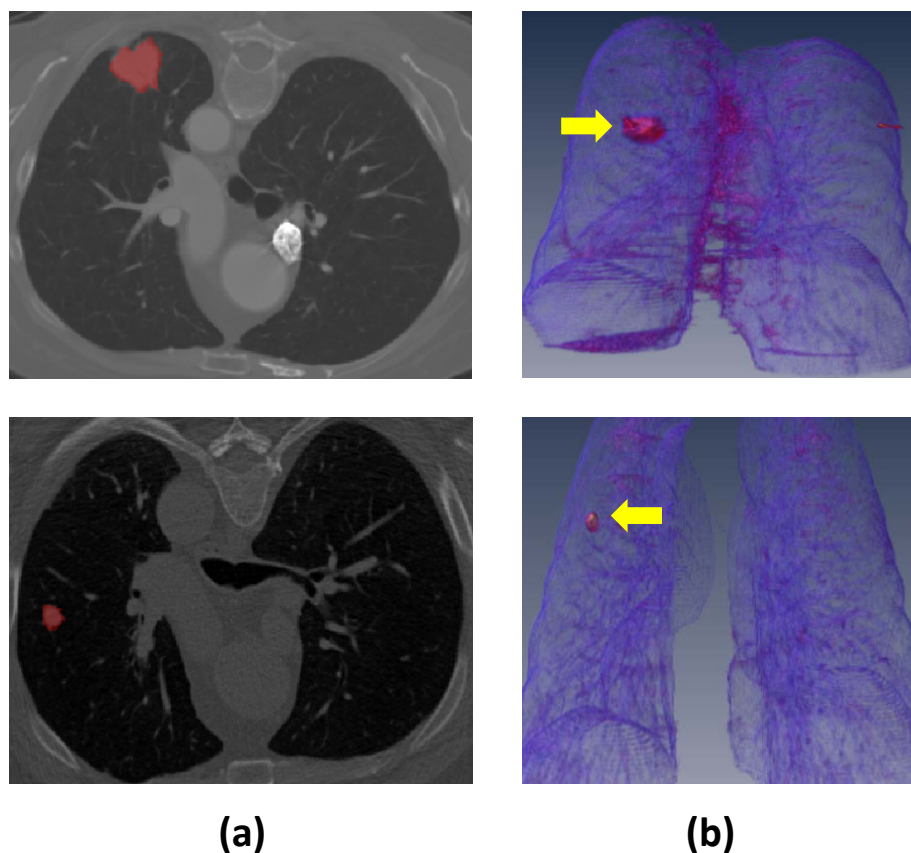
Representation of lung nodules in (a) axial CT slices and in (b) volume renderings. The top row shows malignant nodule where the second row depicts an instance of benign nodule. The nodules are highlighted in red in (a) and are pointed by arrows in (b).
